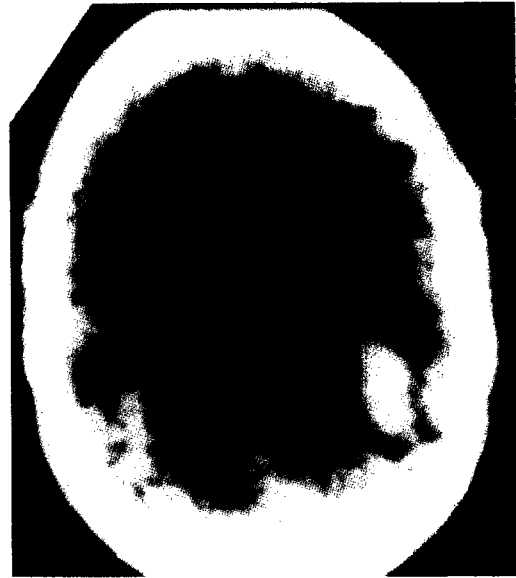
Axial brain CT shows bilateral hemorrhagic radiodense areas in the temporal and occipital lobes, involving visual association cortex and occipito-temporal white matter connections. Patient manifested prosopagnosia and visual recent memory loss, as well as cerebral (central) achromatopsia and bilateral superior altitudinal visual field defects.
